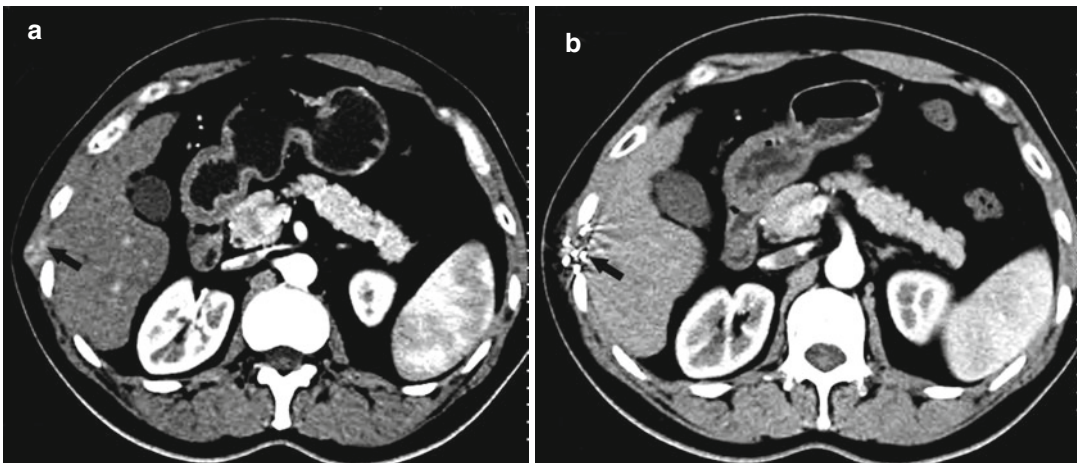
Needle-tract seeding in a 50-year-old man who was previously performed with biopsy for three insertions with primary liver cancer in the deep site. (a) Contrast CT showed heterogeneous high-density seeding nodule
